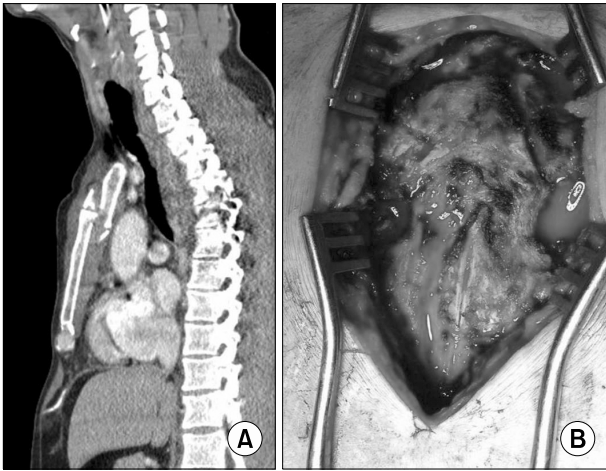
(A) The preoperative computed tomography scan shows a displaced compound sternal fracture. (B) Intraoperative picture of a compound sternal fracture.
